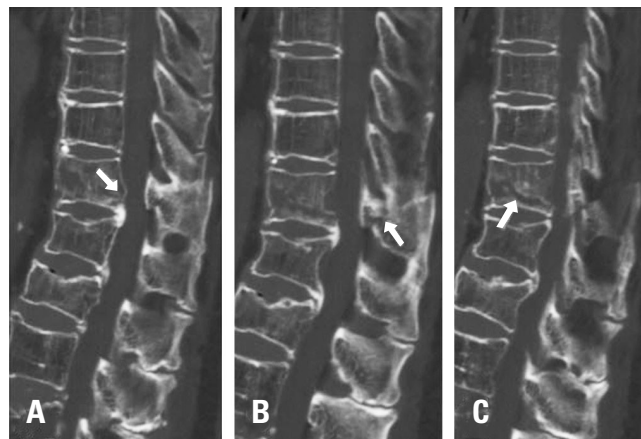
Serial sagittal computed tomography images showing the 3-column fracture with (A) posterior vertebral wall bulging (red arrow), (B) a displaced posterior column fracture, and (C) a collapsing vertebral body.
